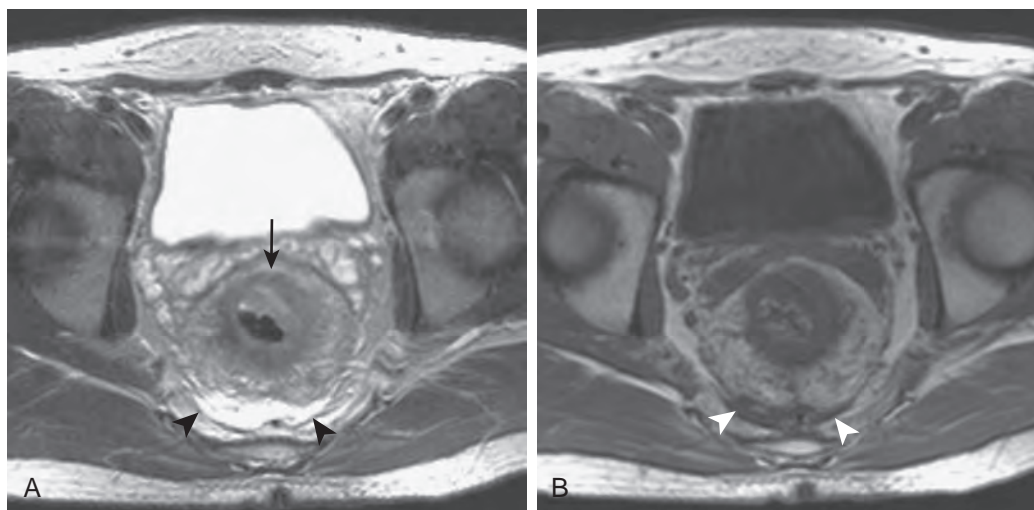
MRI scans of rectal adenocarcinoma with extension into the perirectal fat (T3N0M0; Duke's stage B2) in a patient who underwent neoadjuvant chemotherapy and radiation therapy. A. Axial T2-weighted spin-echo image shows a lobular wall thickening in anterior rectal wall (arrow) and mild thickening of remainder of rectal wall. Outer rectal wall margins are ill defined because of radiation therapy. Mixed signal intensity of perirectal fat with blurring of outer rectal wall and high signal intensity in presacral space are most likely secondary to post-treatment granulation tissue and retroperitoneal fluid. This makes accurate staging of this tumor more difficult. B. T1-weighted image does not suffer from as many postradiation artifacts, as does a T2-weighted sequence. Arrowheads, presacral fluid collection.
